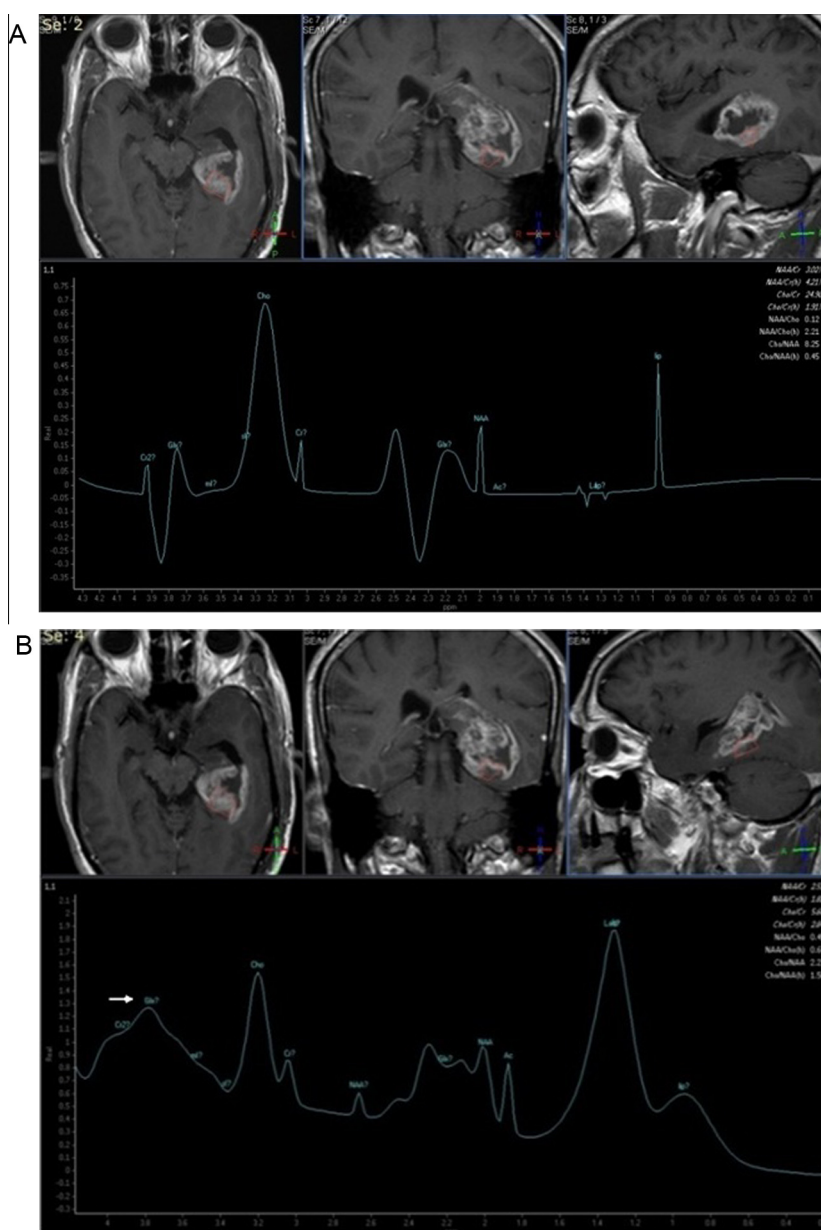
Male patient 37 years old with encephalitis (A & B) MRI and MRS axial post-contrast T1 weighted showed left deep temporoparietal enhanced lesion, and MRS at long and short TR showed: Cho/Cr: 1.7, NAA/Cr: 2.11, Cho/NAA 0.47, prominent lip/lac peak. Mild prominent MI peak, glutamate peak is noted (thin white arrow).
